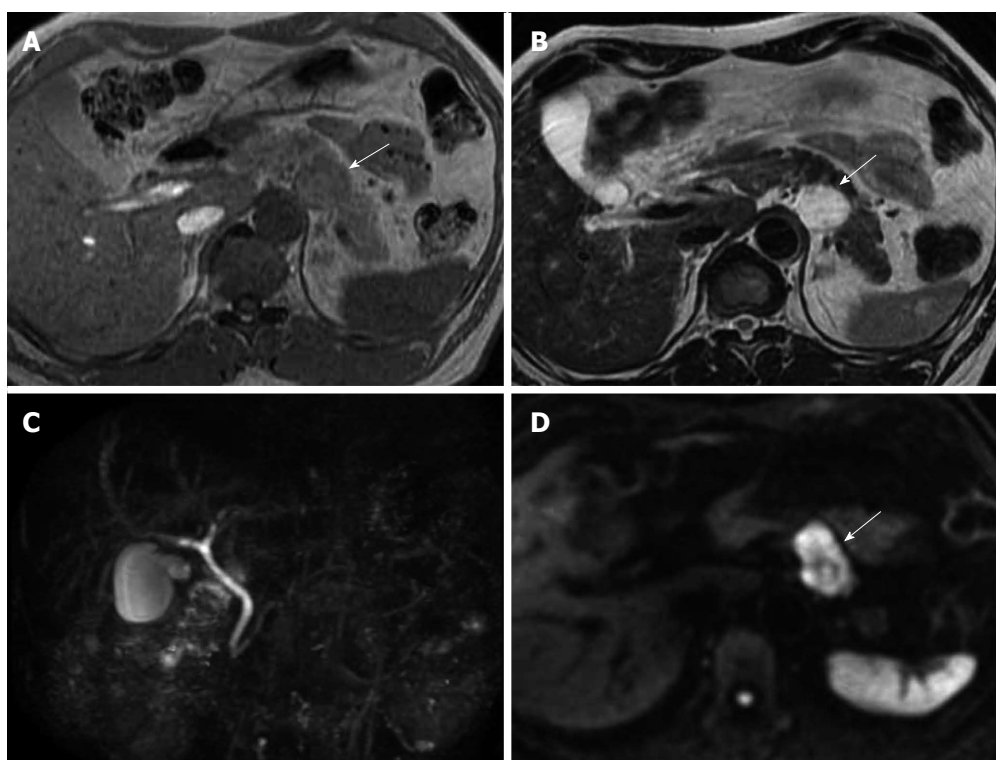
Findings of patient #3. A: Findings of T1-weighted imaging on magnetic resonance imaging (MRI). T1-weighted imaging of patient showed a higher intensity than free water (arrow); B: Findings of T2-weighted imaging on MRI. T2-weighted imaging of patient showed a lower intensity than free water (arrow); C: Findings of magnetic resonance cholangiopancreatography (MRCP). MRCP of patient showed a lower intensity than free water; D: Findings of diffusion-weighted imaging on MRI. Diffusion-weighted imaging of three patients showed a higher intensity than free water (arrow). The cystic lesions showed high intense signal in the central part and iso-intense in the periphery.
